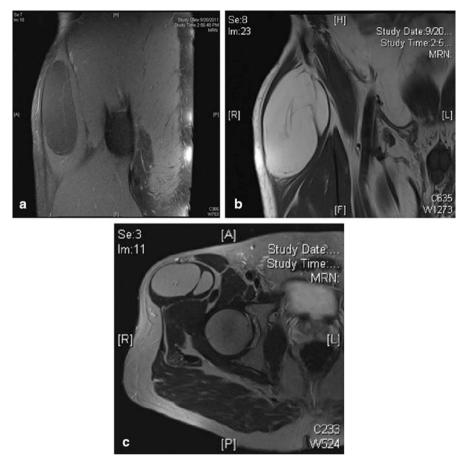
T2 coronal (a) and T1 (b, c) weighted coronal (b) and axial (c) MRI images of a right thigh hibernoma
